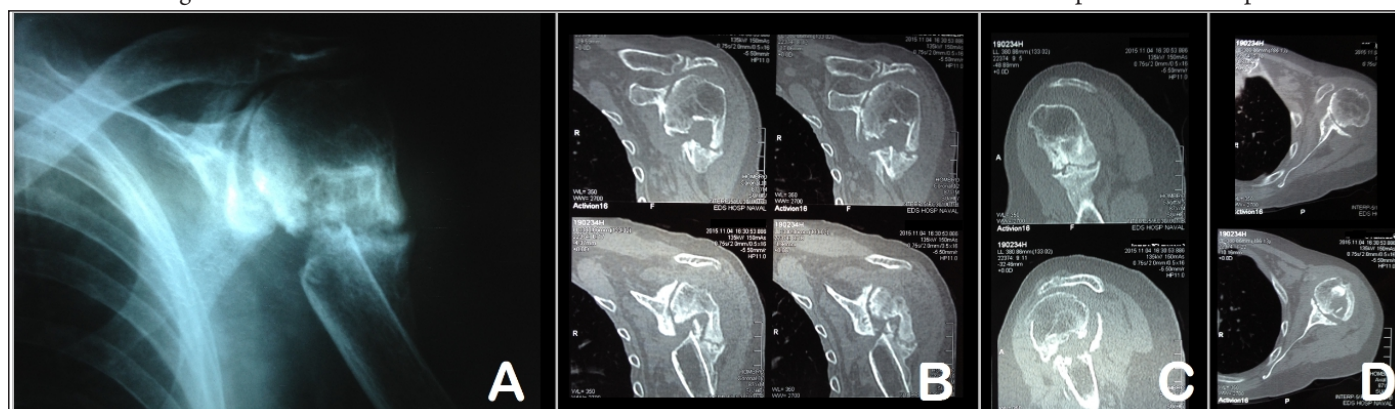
A: Anteroposterior radiograph of a 89 year-old woman with nonunion of proximal humerus taken 14 months after the fracture. The patient had a previous glenohumeral osteoarthritis. The AP radiograph shows a smooth and sclerotic line at the fracture ends with exuberant callus formation. There is some external callus formation present (white arrow). Initial treatment of the fracture included a sling and NSAIDs for pain relief. Surgery was contraindicated because of increased operative or anesthetic risks. B, C and D: CT scan images taken at 15 months after the fracture show respectively a coronal, sagittal and axial views of the hypertrophic callus formation at the fracture site and head bone cavitation).
